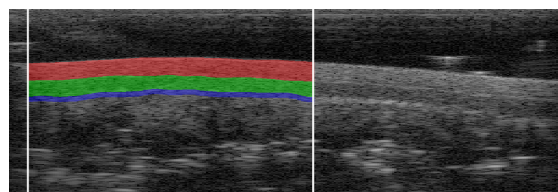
Longitudinal ultrasound image of ganglionic tissue layers, with areas of MI (green), ME (red), and SM (blue) marked as ROI (region of interest).
